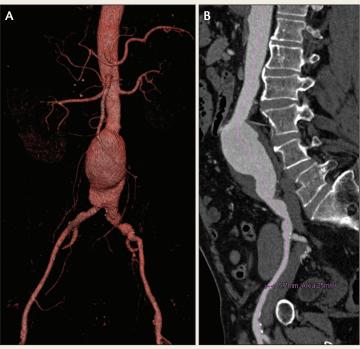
Three-dimensional volume rendering of an AAA with a long neck and without angulations (A). CT centerline reconstruction shows the small external iliac diameters (5.7 mm). Note the common iliac stenosis (3.5-mm lumen) (B).
